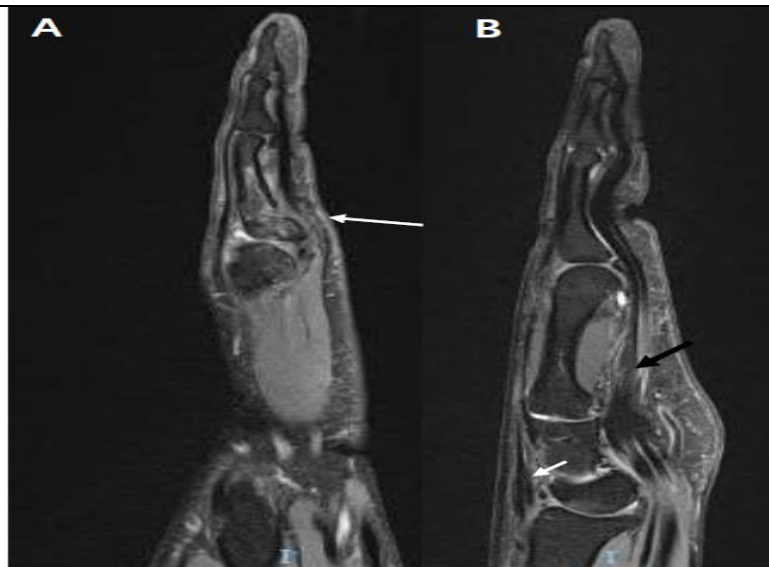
On the left side MRI showed flexor tendons adhesion on healing callous (a white arrow in A and B), on the right, normal finger flexor tendons were free sliding on proximal phalanx, space available between proximal phalanx and flexor tendons and space between FDS and FDP (a white arrow in C).
